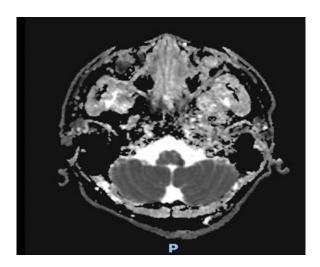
MRI Brain ADC image: focus of hypointense lesion.
